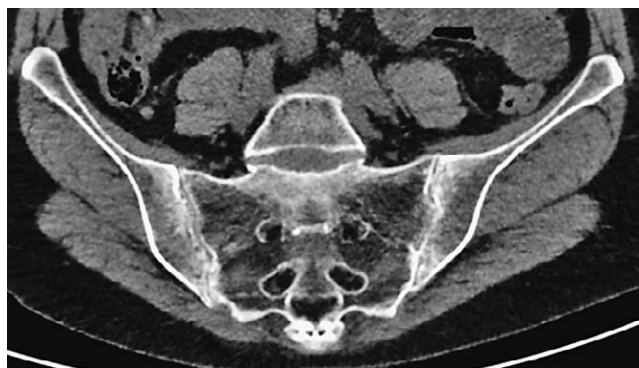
Abdominal CT – coronal MPR image showing bilateral grade III sacroiliitis with joint space narrowing, sclerosis and both sacral and iliac bone erosions
